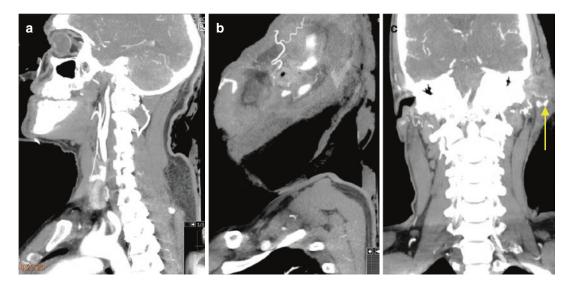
Post contrast CT angiogram sagittal (a, b) and coronal (c) images demonstrating bleeding from the left posterior auricular artery (best seen on image c, yellow arrow)
